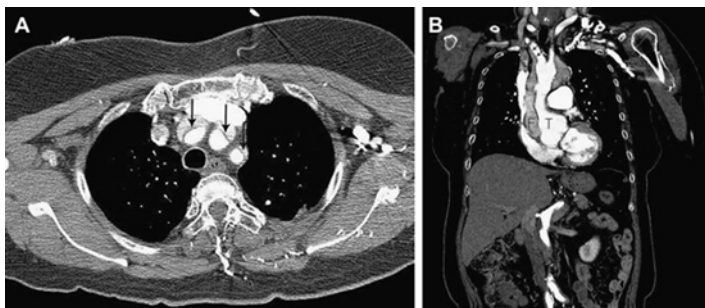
Stanford type A aortic dissection by contrast-enhanced CT. (a) Intimomedial flap (arrows) is noted in brachiocephalic, left common carotid, and left subclavian artery at the level of left brachiocephalic vein. (b) Intimomedial flap (arrows) extending into brachiocephalic artery is noted on coronal image. The contrast enhancement in the true lumen (T) is higher than that of false lumen (F) (Reprinted from Yoo et al. [74], with permission from Elsevier)
